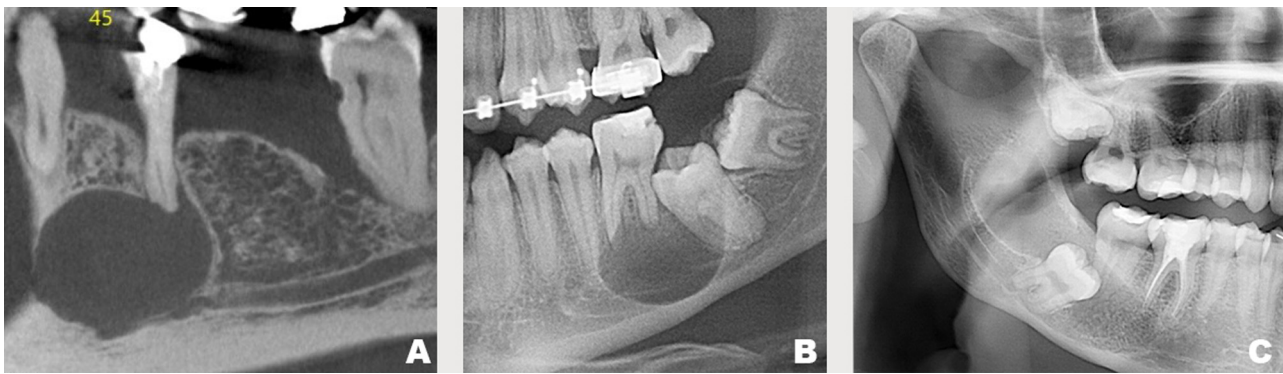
Radiographic features of odontogenic cyst lined by a non-keratinized malpighian lining. (A) Sagittal section of a cone beam computed tomography (CBCT) showing an unilocular radiolucency at the root apex of tooth 45. The final diagnosis was a radicular cyst. (B) Panoramic view showing a well-defined unilocular radiolucency involving the furcation of a partially erupted molar (37). The final diagnosis was an inflammatory collateral cyst. (C) Panoramic view showing a unilocular radiolucency surrounding the crown of a non-erupted molar. The final diagnosis was a dentigerous cyst.
